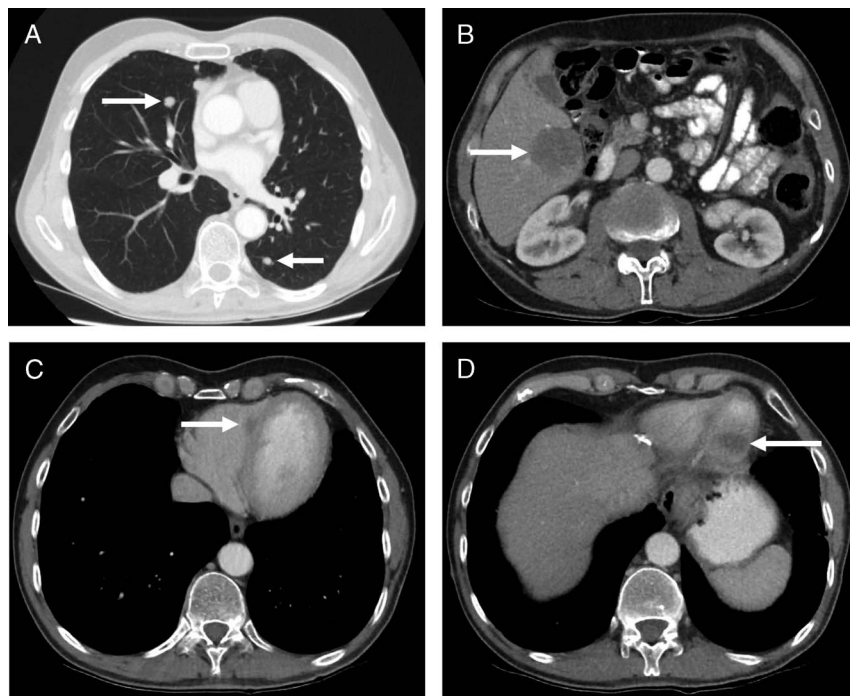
Adenoid cystic carcinoma (ACC) is a rare cancer that occurs most often in the salivary glands, but can also arise from other secretory glands, for example, in the bronchus. Adenoid cystic carcinoma is known for its often indolent growth, and patients can remain asymptomatic for years, even with distant metastases, which mainly occur in the lungs and bones.^{1,2} A 55-year-old man with metastatic ACC arising from the left bronchus previously received tumor resections of the primary tumor in 2011 and of the liver (in 2013) and subcutaneous metastases (in 2014). From 2015, very slow-growing metastases arose in the liver, spleen, lungs, and bones. Because of relatively stable disease and no disease complaints, the patient did not receive systemic therapy,³ but was under active surveillance with contrast-enhanced CT of the chest and abdomen every 3 months. During one of these scans in 2017, cardiac lesions were observed and suspected to be metastases. Cardiac metastases in ACC patients are extremely rare; only one other case is described in literature.⁴ A shows lung metastases, B shows a liver metastasis. C and D show lesions in the cardiac septum and left ventricle wall. In retrospect, these lesions were also present on scans from 2014 and increased in size over time.
